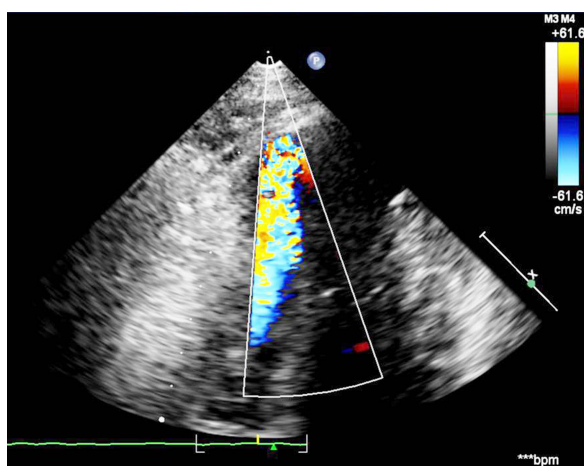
Parasternal long-axis apical view colour Doppler imaging showing apical septal defect with left to right shunt.
